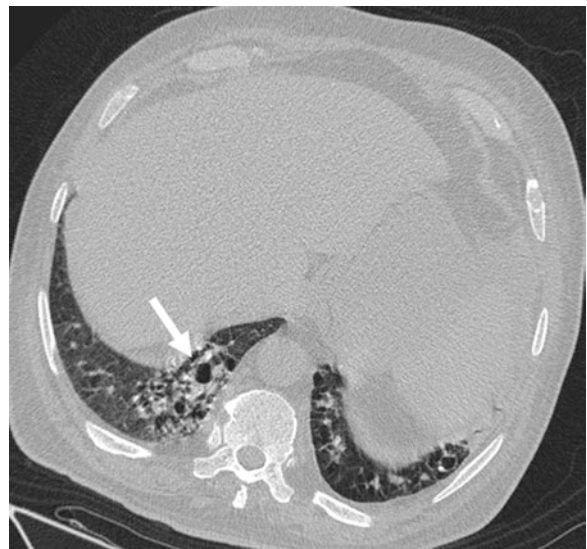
Axial chest CT in COVID-19 patient. There is a right lung base opacity in association with foci of small air densities within the lesion compatible with the “air-bubble sign”
